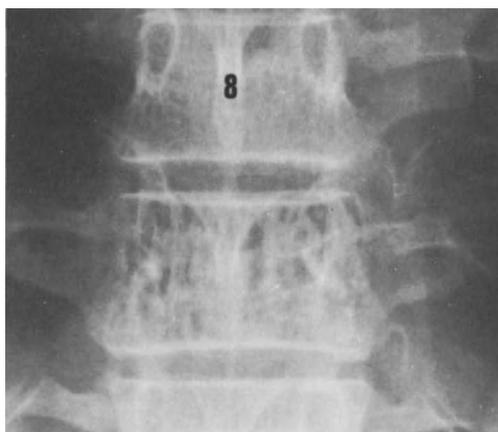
Angiomatous vertebra (D9). *Left:* plain film; *right:* native scan
